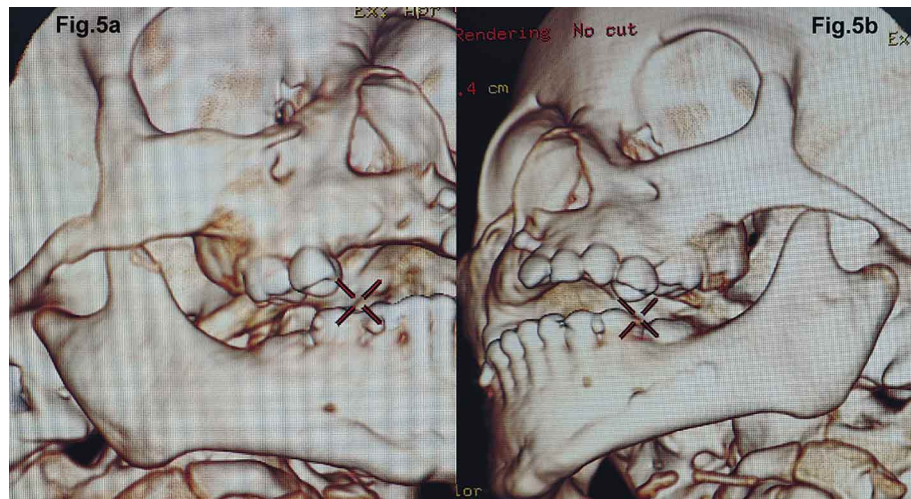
CT after 3 months of treatment. a) Right side. b) Left side.
